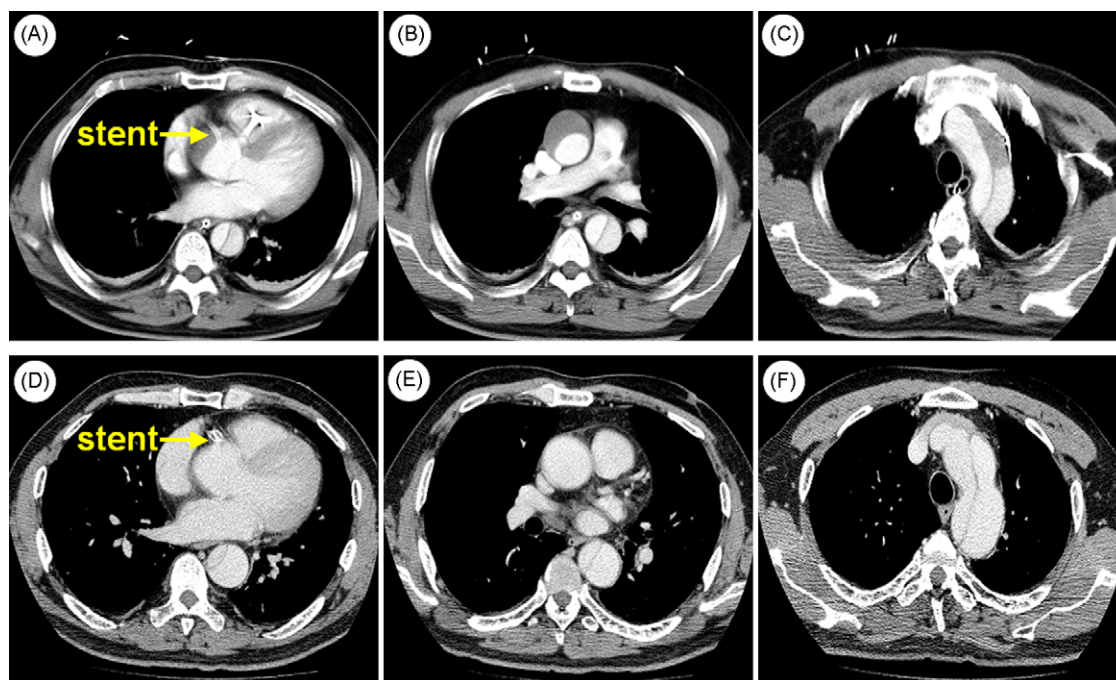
(A–C) Contrast-enhanced computed tomography (CT) images after stenting. (D–F) Contrast-enhanced CT images at six months. (A and D) The implanted bare metal stent (arrow) was observed clearly at the level of the right coronary cusp. (B) A chest CT scan showing characteristic crescentic wall thickening with an ascending aortic intramural hematoma and intimal flap with flow communication in the descending aorta. (C) At the level of the distal aortic arch, the thrombosed false lumen became patent with flow communication. (E) A chest CT scan showing complete resorption of the ascending aortic intramural hematoma and intimal flap with flow communication in the descending aorta. (F) A false lumen with flow communication was observed at the level of the distal aortic arch.
